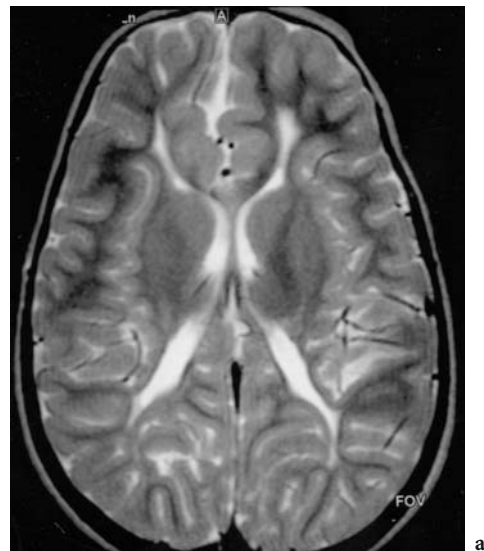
a Axial, b coronal T2-/FSE MRI. Follow-up in 4-year-old term infant following severe perinatal asphyxia, with moderate cerebral palsy and visual impairment. There is a marked asymmetrical loss of occipital white matter, but also signal alteration of the periventricular frontal white matter
